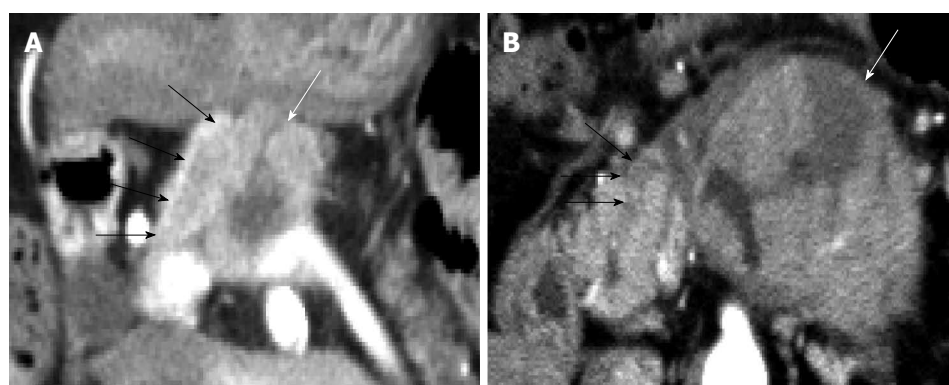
Acinar cell carcinomas with intraductal tumor growth. A: Case 6, computed tomography (CT) showed the primary acinar cell carcinoma (ACC) in the pancreatic body (white arrow) and the easily recognizable widespread intraductal tumor growth (ITG) (black arrows); B: Case 5, CT shows the primary ACC in the pancreatic body (white arrow) and the small almost-unrecognizable ITG (black arrows).
